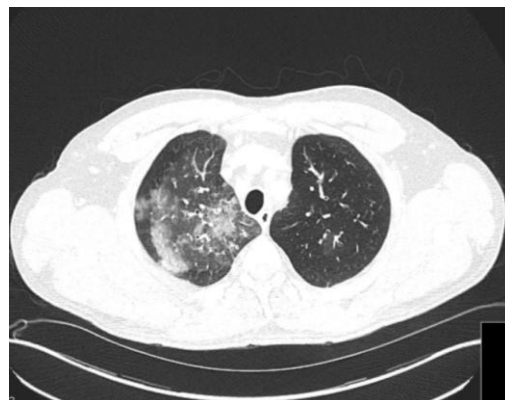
CT chest performed on second admission showing multifocal areas of patchy consolidation and ground glass change involving upper lobes bilaterally but more on the right
